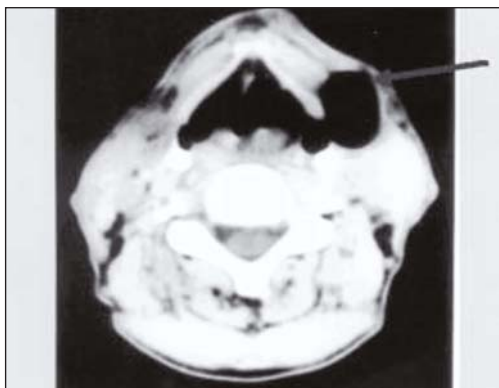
Axial CT of Neck showing Laryngocle.
